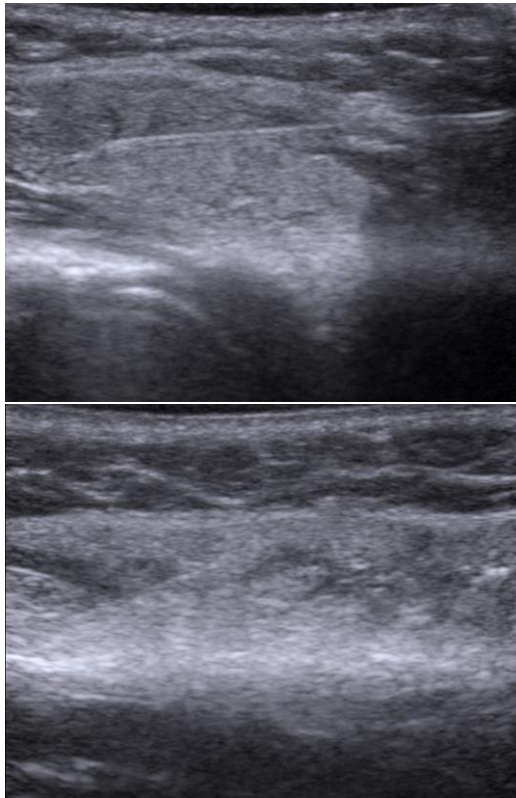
Ultrasound guided intraparotid Botulinum Toxin A injection. The
